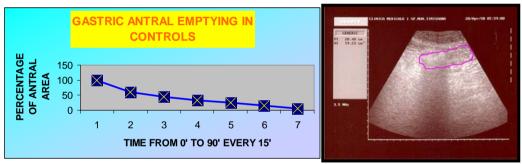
Antral motility in controls (mean values percentage T½) and ultrasound feature
